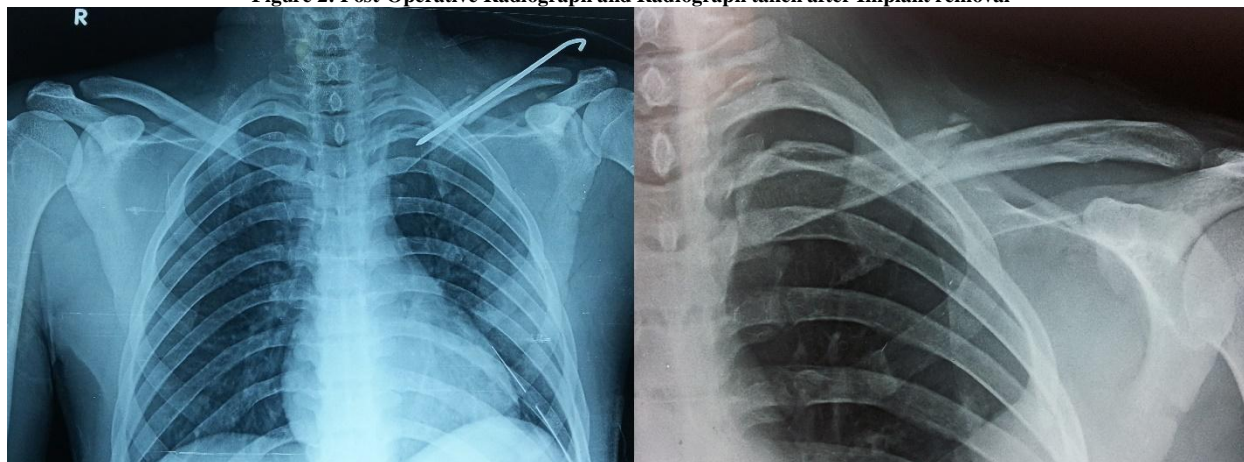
Post-Operative Radiograph and Radiograph taken after Implant removal
